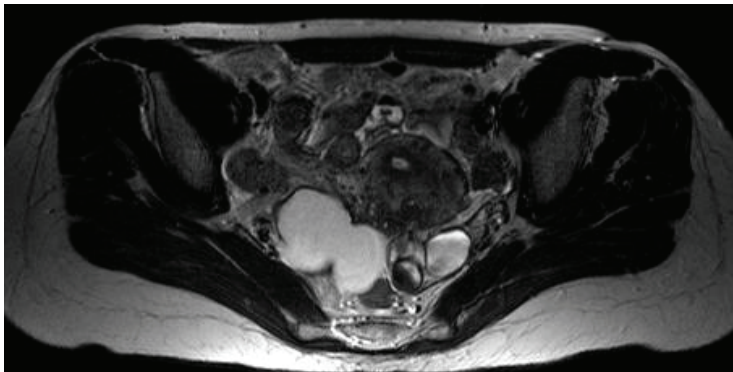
T2-weighted image acquired on the transverse plane, showing hyperintense bilateral endometrioma masses on the ovaries that are closed up due to interovarian adhesions (Kissing ovaries).
